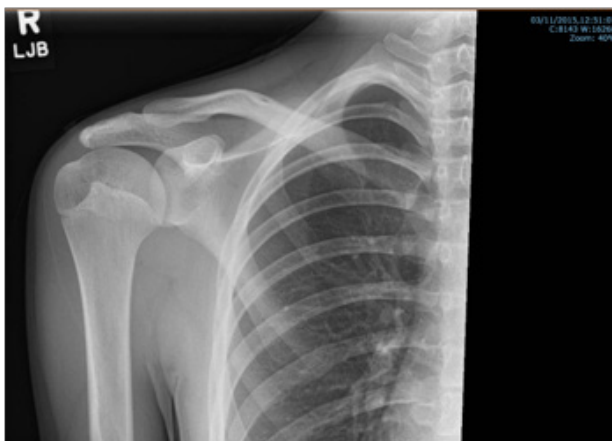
Plain AP radiograph of right shoulder obtained at initial presentation.
